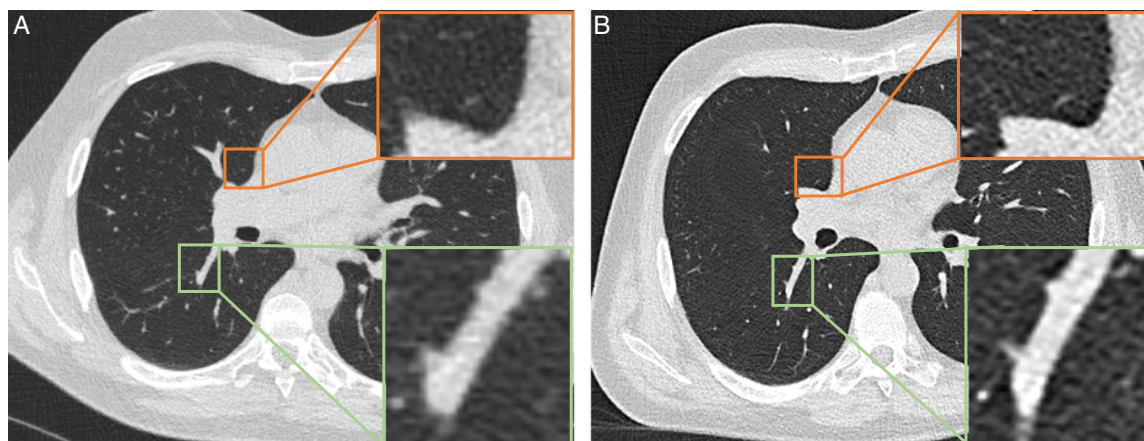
Example images for EID-CT (A) and PCD-CT (B) with a focus on visually sharp reproduction of the vessels (green boxes) and the pleuromediastinal border (orange boxes). The time between the acquisition of both scans was 97 days. $CTDI_{vol}$ was 1.5 mGy for the EID-CT scan and 0.8 mGy for the PCD-CT scan. The patient’s BMI was within the category “overweight” and increased ~ 0.9 kg/m² between both scans. [full color online](#)
